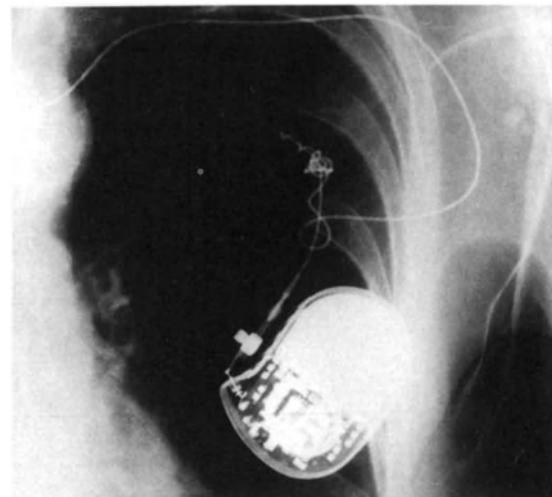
Chest radiograph of a patient with rising pacing thresholds requiring repeated pacemaker insertion. There is an epicardial system (solid arrow), a redundant epicardial electrode (arrowhead), a permanent endocardial system (open arrow) with a screw tip wire (curved arrow), a redundant permanent endocardial wire and a temporary pacing wire.
